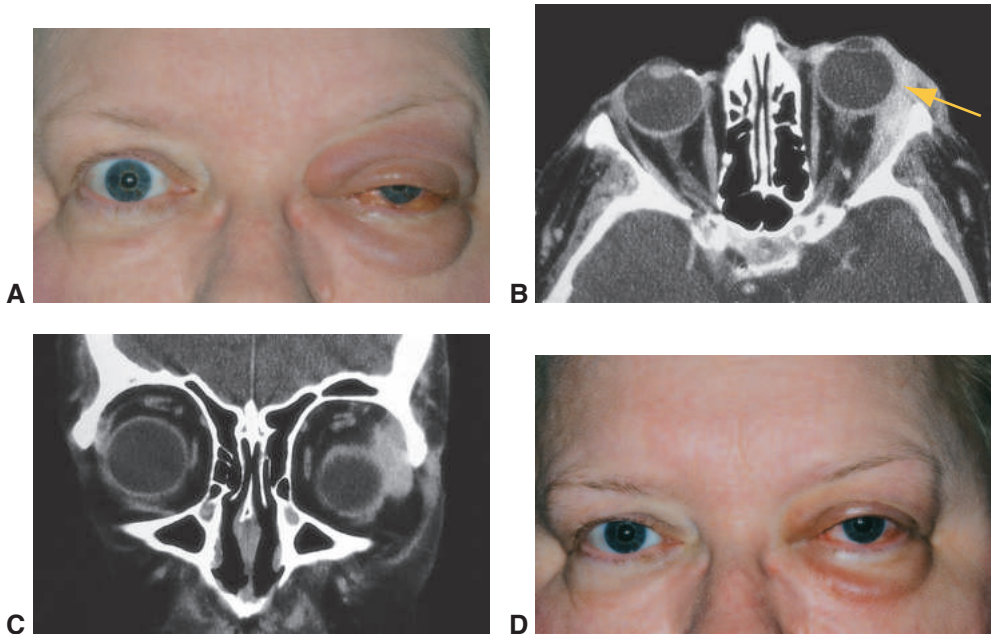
NSOI. A, A patient presenting with acute onset of inflammation of the left eyelid, proptosis, pain, and left lateral rectus paresis. B, Axial CT scan shows left-eye proptosis and hazy inflammatory edema of the lacrimal gland and lateral rectus (involving the muscle tendon; yellow arrow), suggestive of a diagnosis of NSOI. C, Coronal CT scan shows inflammatory process adjacent to the lateral rectus. D, Marked improvement of inflammatory changes demonstrated in the patient after a 48-hour course of oral prednisone. (Parts A and D courtesy of Keith D. Carter, MD; parts B and C courtesy of Robert C. Kersten, MD.)
